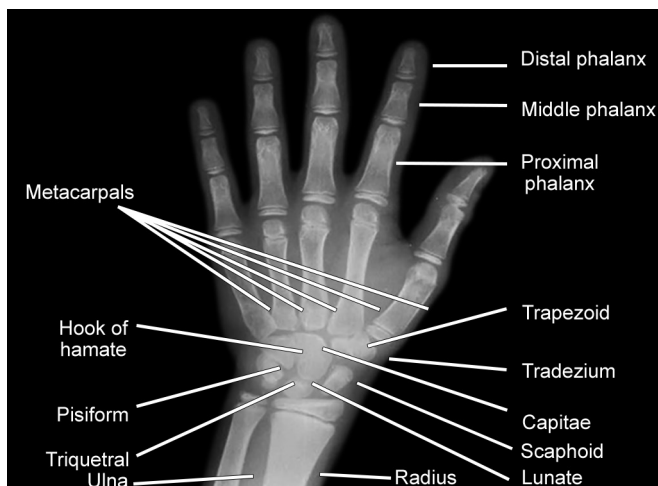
Hand-Wrist X-ray with phalanges, carpals, and metacarpals
